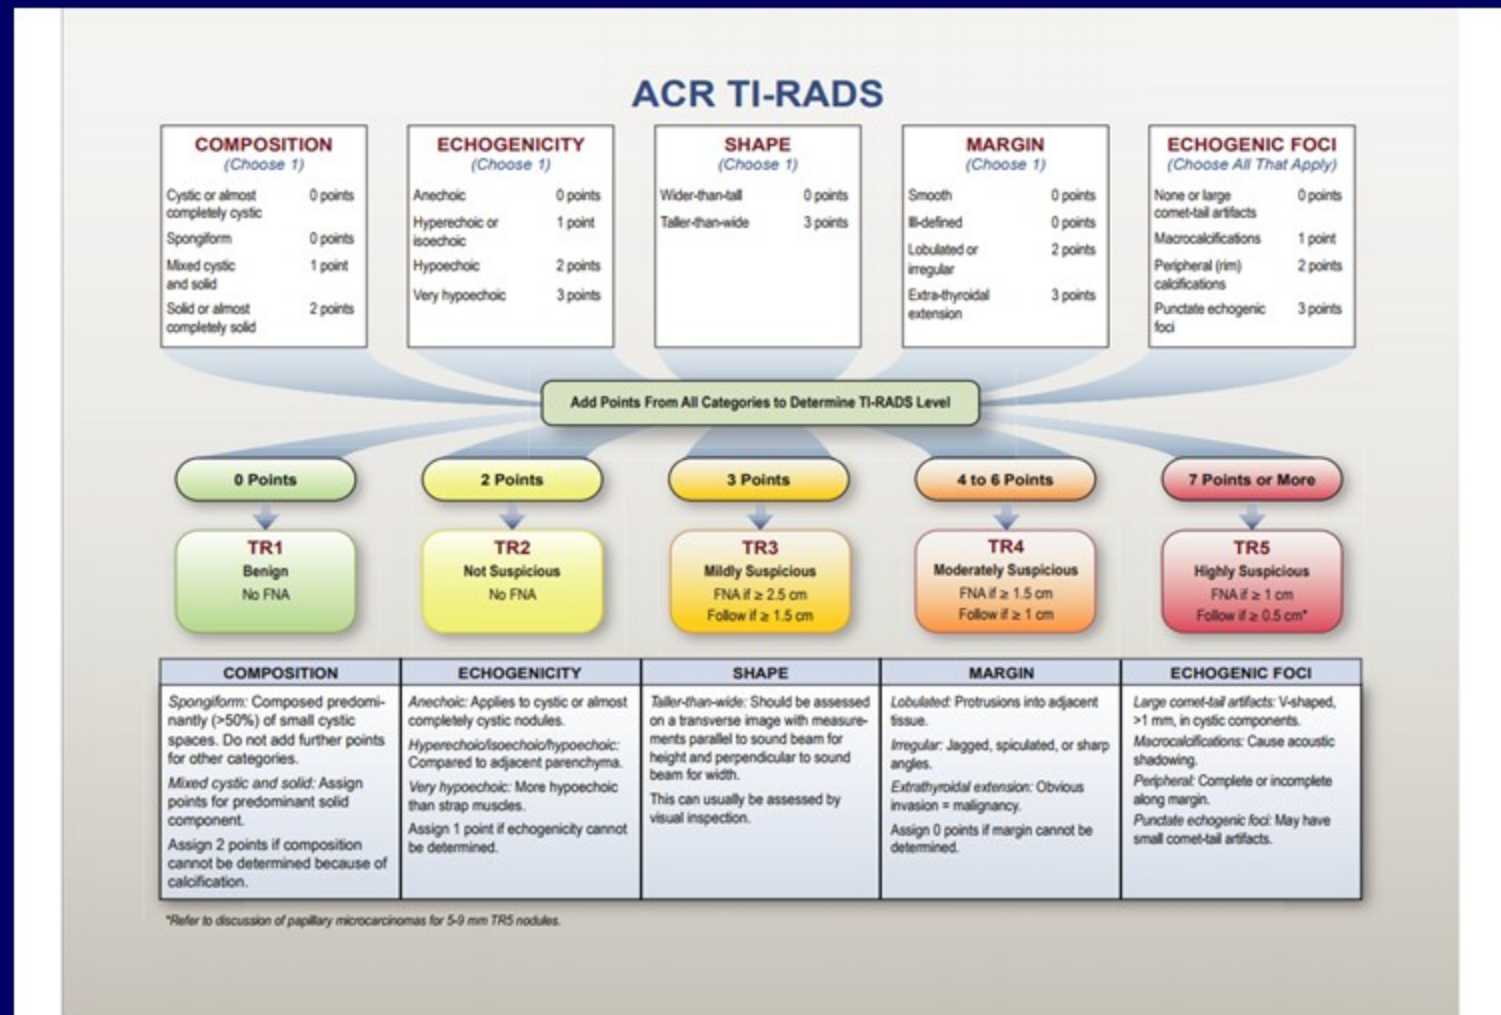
Chart showing five categories on the basis of the ACR Thyroid Imaging, Reporting and Data System (TI-RADS) lexicon, TR levels, and criteria for fine-needle aspiration or follow-up ultrasound. Explanatory notes appear at the bottom.
